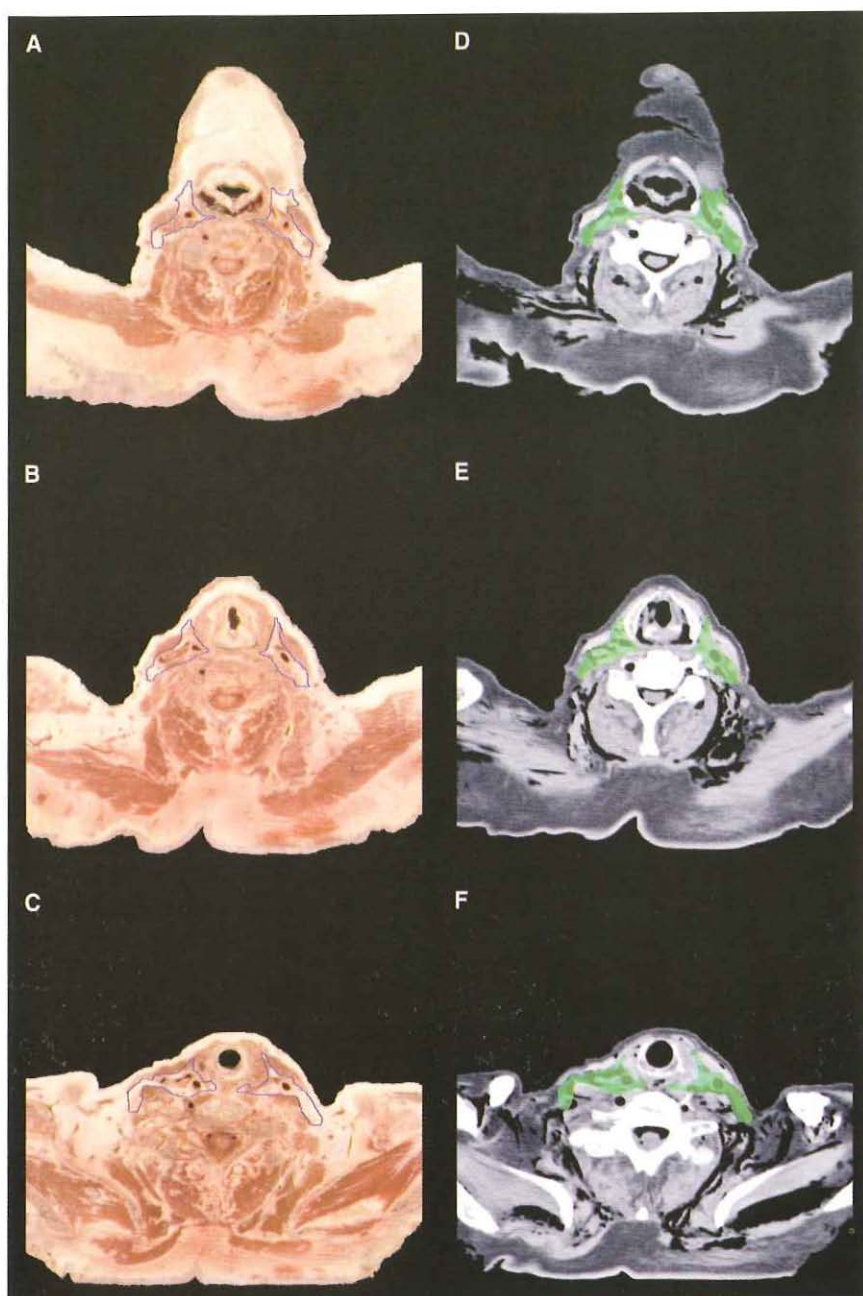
Region 3: borders are in blue outline on the anatomy slices (left) and in green color-wash on the CT slices (right).
